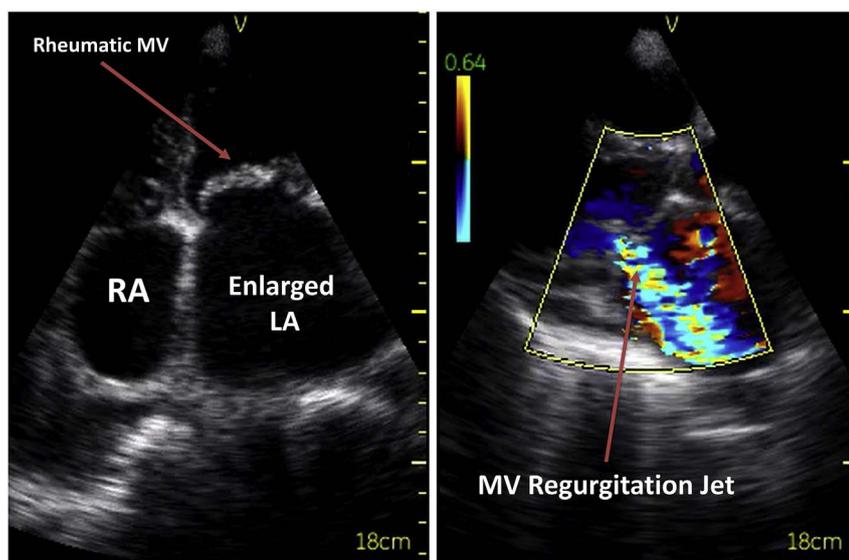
Focused cardiac ultrasound performed on 40 years female admitted due to dyspnea and palpitations. Severe left ventricle dysfunction, left atrial dilatation and mitral valve regurgitation and stenosis, most probably of rheumatic origin, were diagnosed. RA-Right Atrium; LA- Left Atrium; MV- Mitral Valve.
